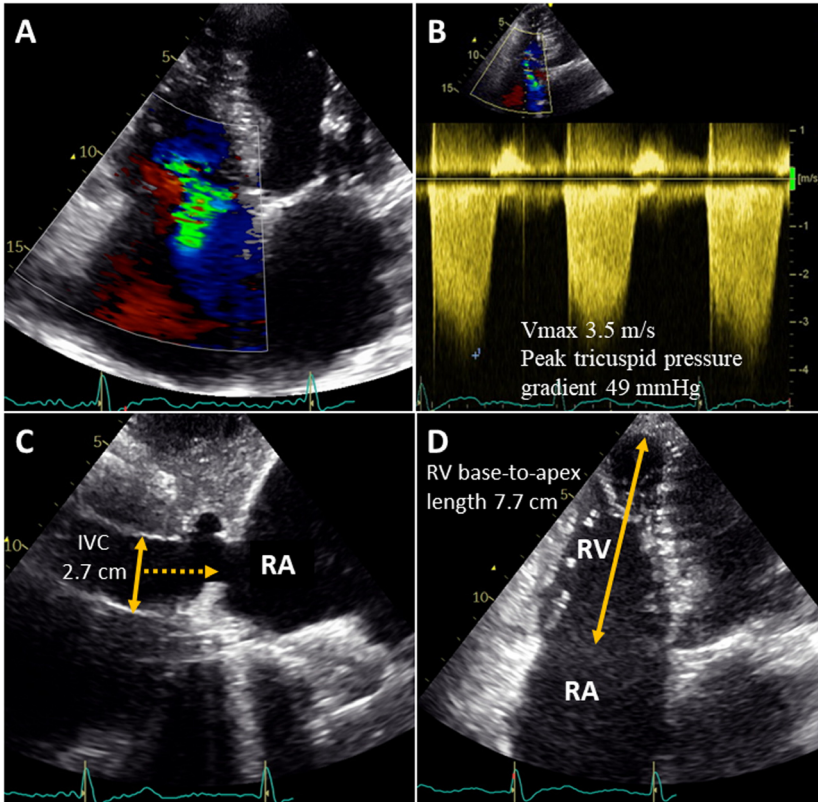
Echocardiographic images of a male patient with severe tricuspid regurgitation. Despite severe tricuspid regurgitation, only a mild systolic murmur was hearable. A is apical 4-chamber view showing dilated RV and RA, and tricuspid regurgitant jet by color Doppler. B is a continuous wave Doppler signal through tricuspid valve and shows a TR Vmax of 3.5 m/s and peak tricuspid pressure gradient of 49 mmHg. C is subcostal view showing slightly dilated IVC of 2.7 cm (RA pressure was 10 mmHg based on the inspiratory changes in the dimension of inferior vena cava), yielding a systolic pulmonary artery pressure of 59 mmHg. D shows RV base-to-apex length of 7.7 cm. IVC, inferior vena cava; RA, right atrium/atrial; RV, right ventricle/ventricular; TR Vmax, peak velocity of tricuspid regurgitant jet.
